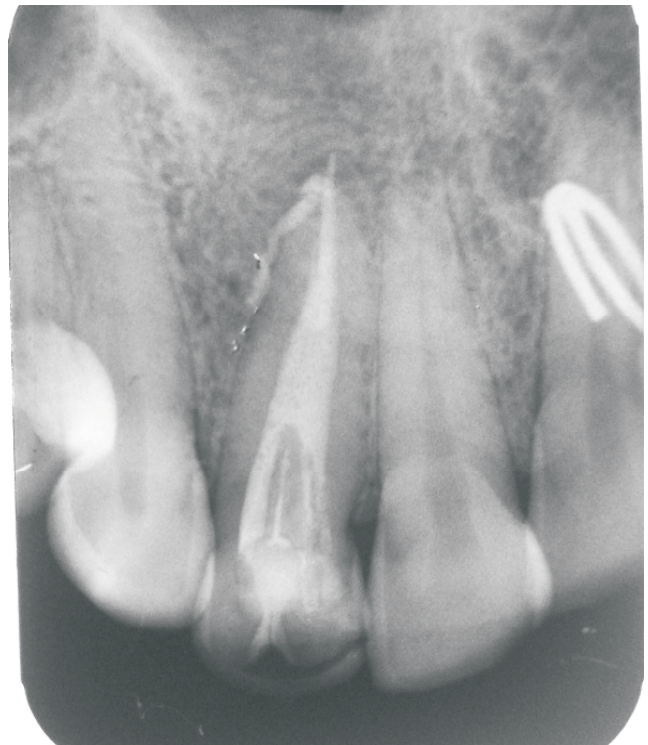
One year follow up radiograph showing remarkable healing of the periapical lesion.
